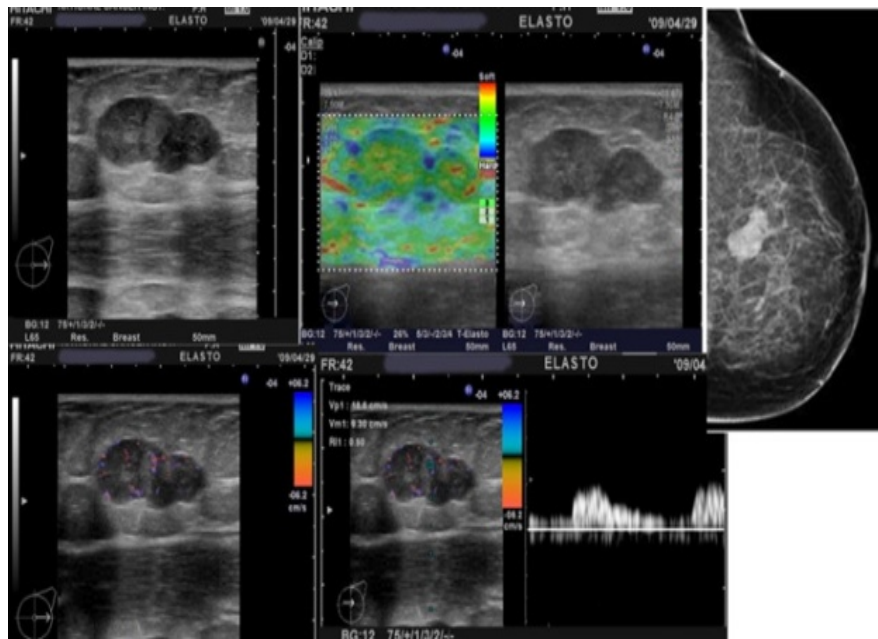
showing 53 years old woman presented with clinically left breast mass, Mammography showing ACR pattern 3; descriptive criteria include an oval macro-lobulated dense well defined left breast mass. B-mode U/S showed an oval parallel lobulated hypo-echoic focal lesion. Lesion Size: 35 × 18 mm. Doppler Color score: 2 & RI: 0.5 U/S elastography: UE score 2. Final combined (B-mode US, Doppler US & UE) diagnosis shows probably benign. Pathological diagnosis: Invasive duct carcinoma.
